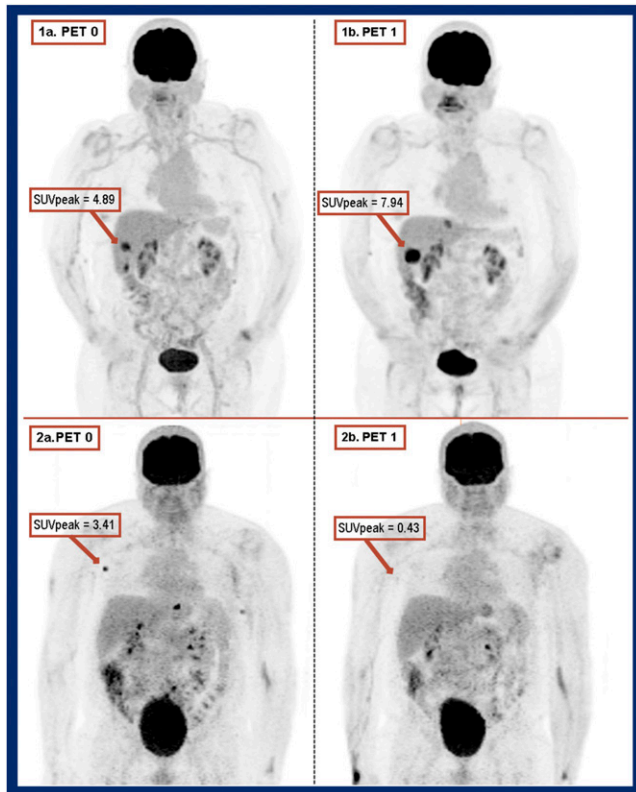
Evaluation of ^{18}F -FDG PET/CT for response assessment in patients with advanced melanoma treated with pembrolizumab checkpoint inhibitor monotherapy. Maximum-intensity projection images show progression and response in patients before initiation of therapy (left) and after 3 cycles of treatment (right). Top: 88-year-old patient with melanoma metastatic to the liver. Progressive disease was seen after 3 cycles. Disease ultimately progressed during therapy. Bottom: 58-year-old patient with metastatic disease to an axillary lymph node. After 3 cycles of therapy the patient showed a complete response on imaging. The patient later was classified as having no evidence of disease.
